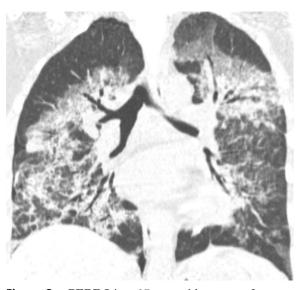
PERDS in a 27-year-old woman after HSCT. Coronal HRCT image shows bilateral peribronchial ground-glass opacities with a predominant perihilar and lower lobe distribution.
